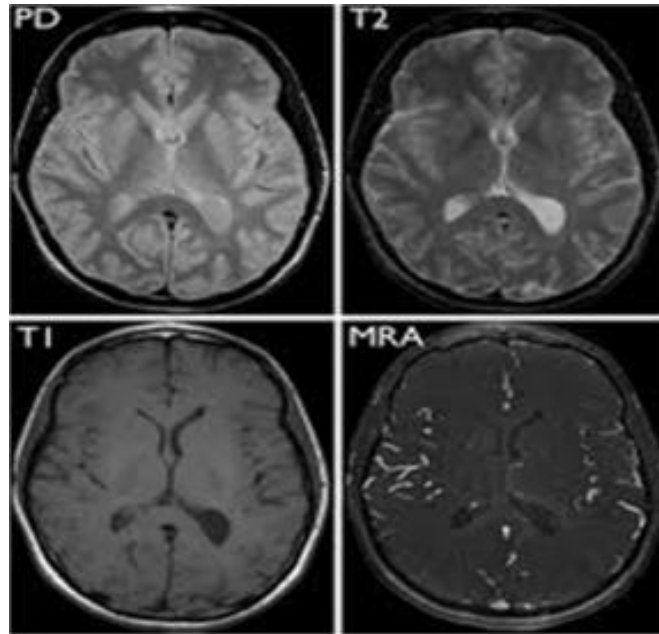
Different weighted MRI image
